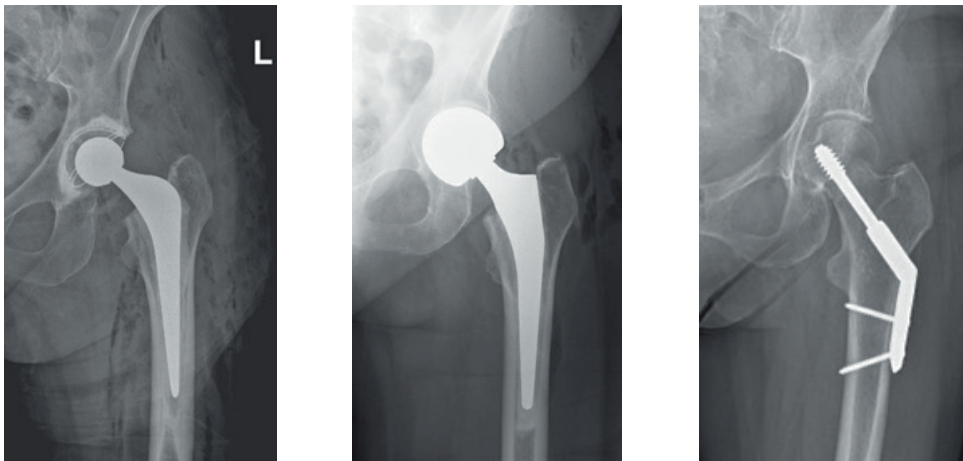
Radiograph of a total hip arthroplasty (left), a hemiarthroplasty (middle) and an internal fixation by means of a dynamic hip screw (right).
